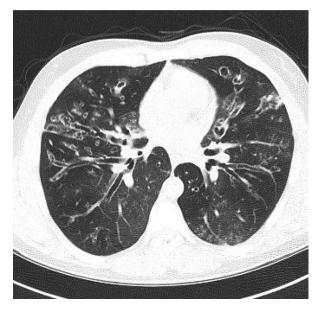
Tram-track sign seen in cylindrical bronchiectasis on the chest CT scan in a patient with advanced cystic fibrosis.
